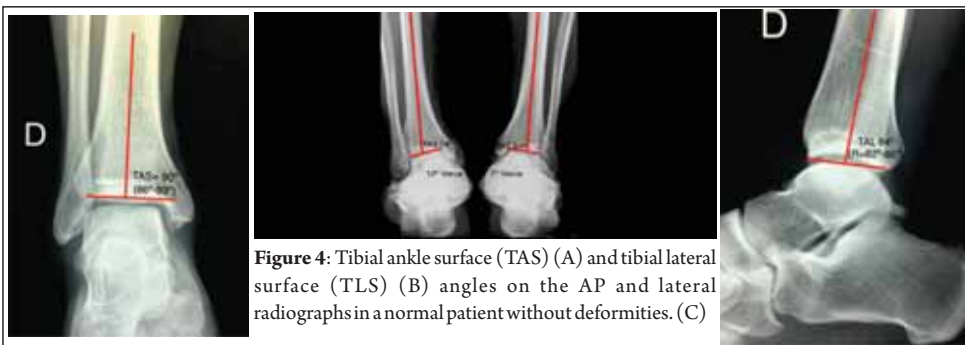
Tibial ankle surface (TAS) (A) and tibial lateral surface (TLS) (B) angles on the AP and lateral radiographs in a normal patient without deformities. (C)
